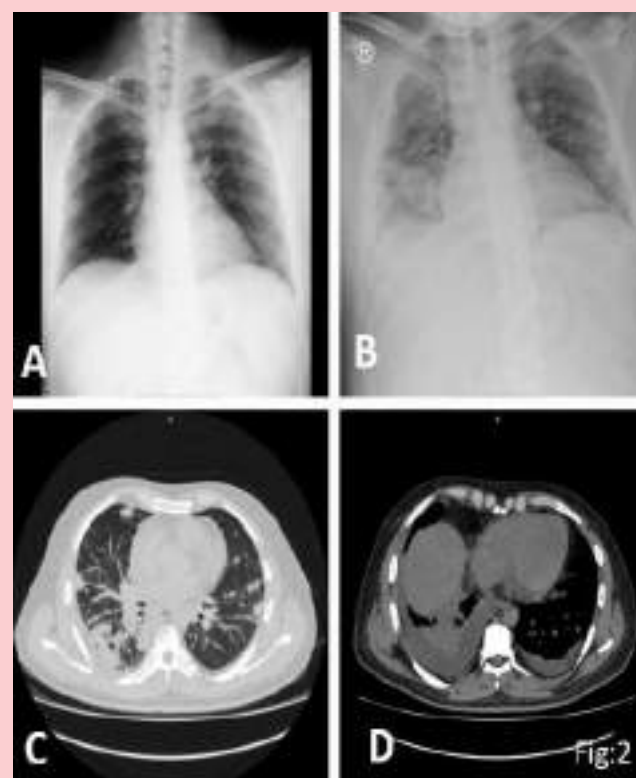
2-A-normal CXR on day of admission. B-2 days later CXR taken when patient had shortness of breath, shows multiple rounded nodules in bilateral lung fields, predominant in peripheries. C- HRCT image showing multiple subpleural hyperdense nodules in bilateral lung fields, one of nodule is showing cavitation as well. D- bilateral pleural effusion.
